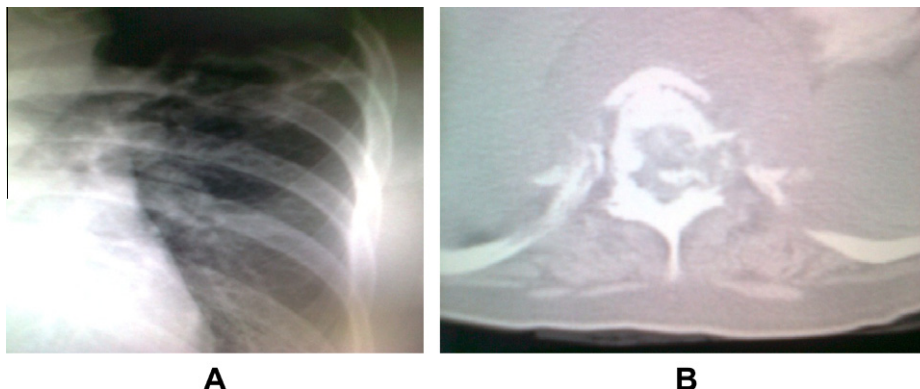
(A) Chest X-ray showing left sided tuberculous infiltrates. (B) CT scan-showing spinal tuberculosis leading to Pott's disease.
